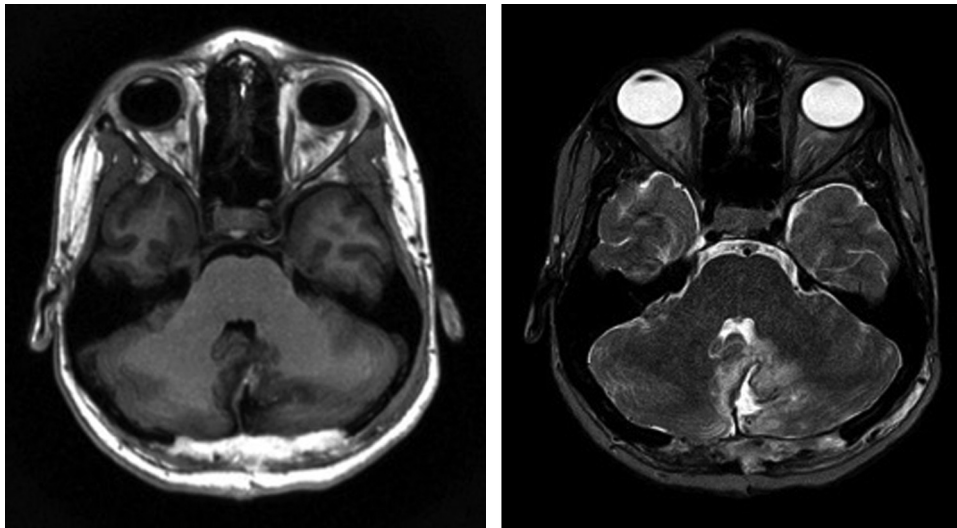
Left: T1 W contrast-enhanced axial MRI. Right: T2 W MRI.
